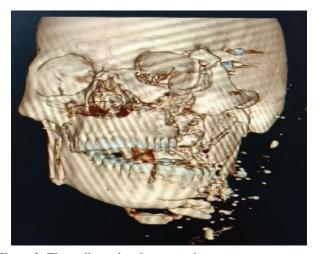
Three-dimensional computed tomogram reconstruction of head and neck
